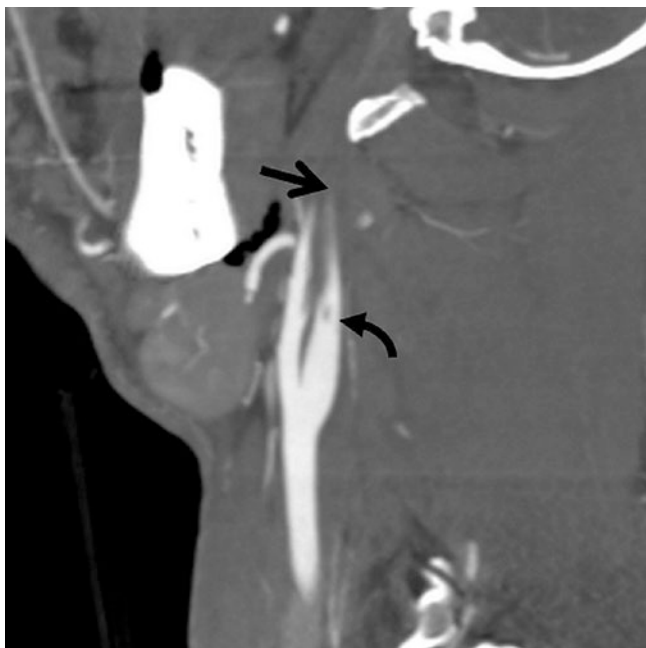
Grade IV ICA injury. Sagittal reconstructed CTA demonstrates tapered occlusion of ICA, consistent with grade IV injury (arrow). Note is made of a small intraluminal thrombus (curved arrow)
